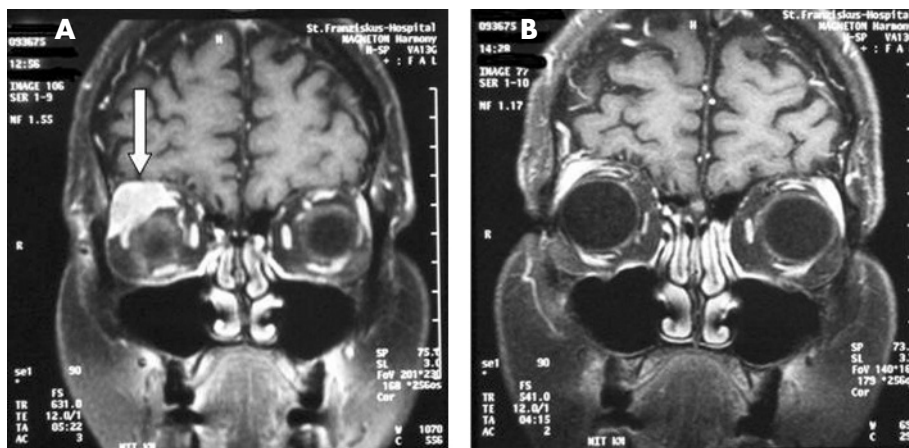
Coronal contrast-enhanced T1-weighted MR image shows MALT lymphoma (arrow) before therapy (A) and 12 months later (B).
